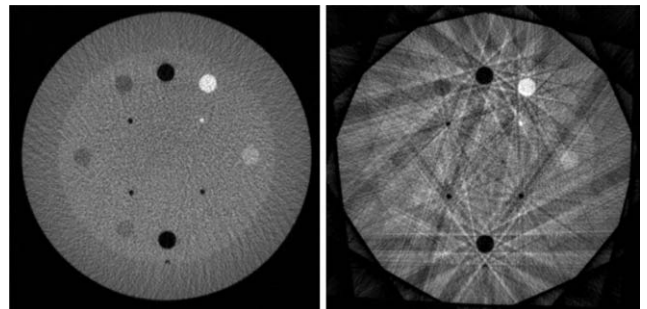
Comparison of four-dimensional cone-beam computed tomography images acquired with speed 1°/s tube current 10 mA (left) and speed 8°/s tube current 80 mA (right).
